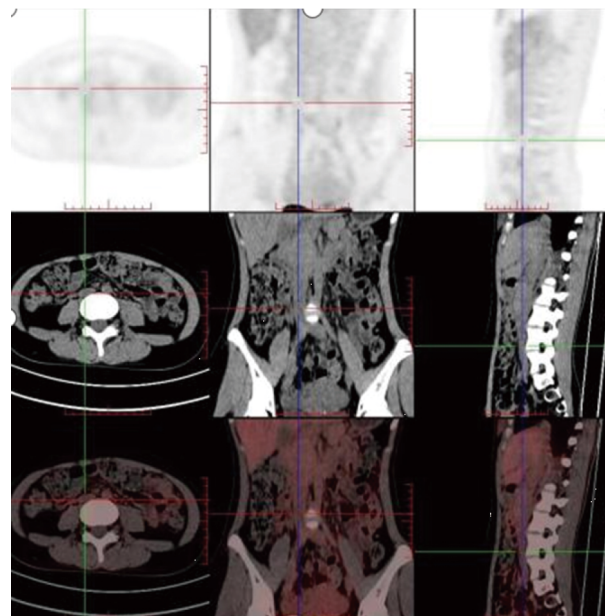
Positron emission tomography/computed tomography showed a low-density lesion was observed in the lower segment of the inferior vena cava extending to the left common iliac vein, showing general radiopharmaceutical uptake with an SUV_{max} of 1.7.
